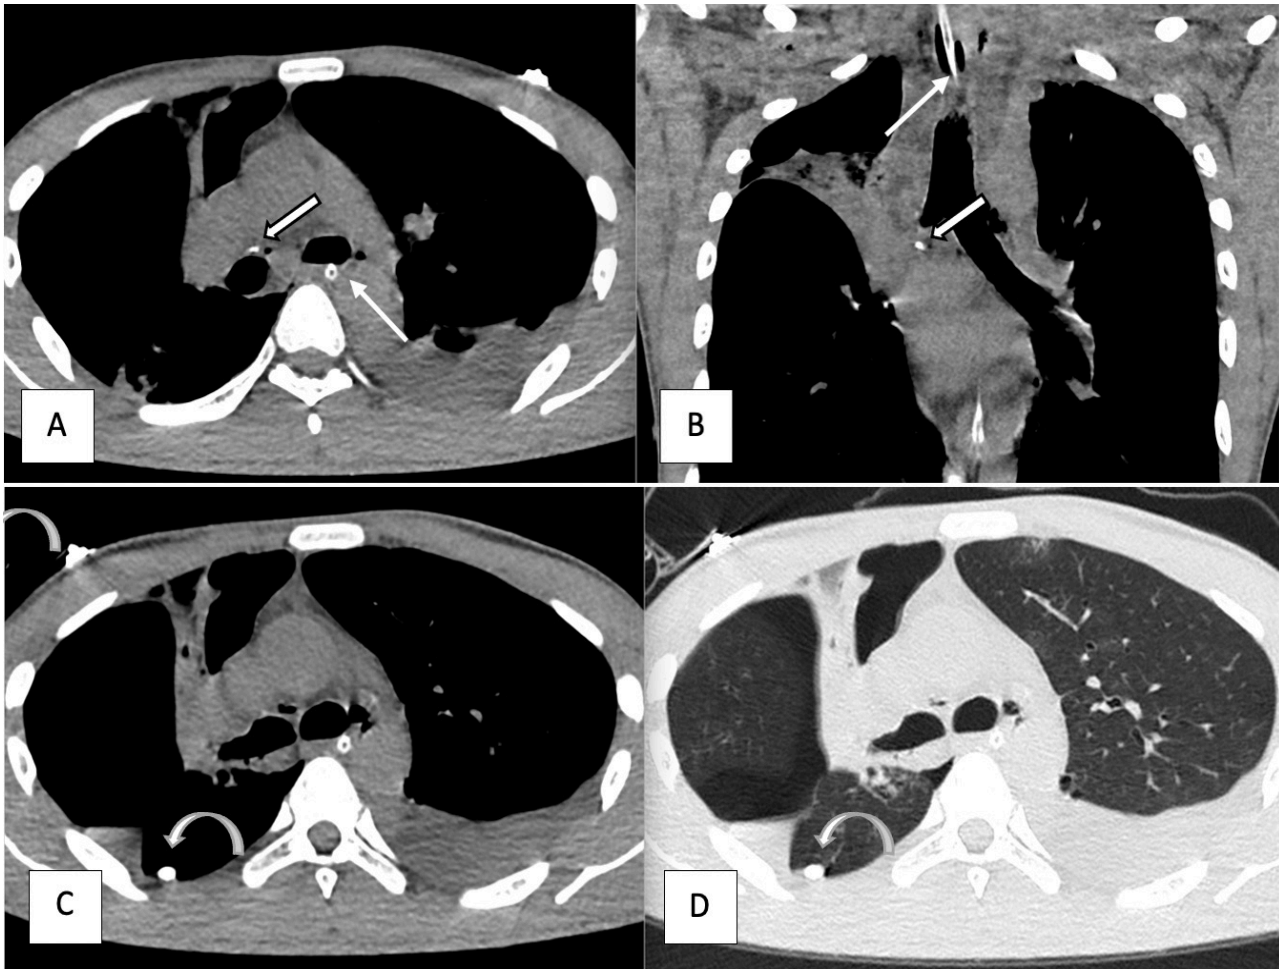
Non-contrast CT thorax at the level of carina in axial and coronal (A - D), show multiple high-density materials at the right hilar region adjacent to the right main bronchus (straight arrow) and at posterior costal pleural surface of the right lower lobe (curved arrow) representing the intrathoracic migration of foreign bodies. Lung contusions with collapse associated with right pneumothorax are also seen (D). Nasogastric tube (white long arrow) within the esophagus shows no communication with the adjacent trachea.
